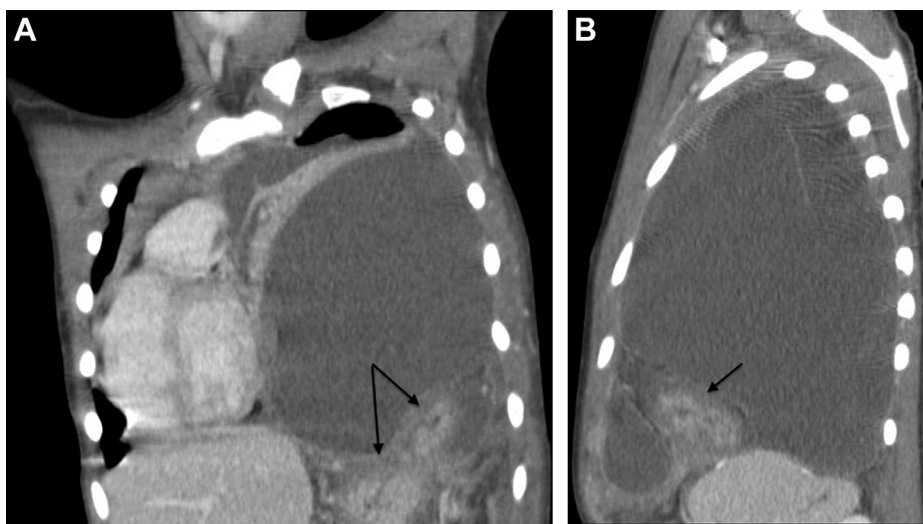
CT scan of the chest showing large simple left thoracic fluid collection with evidence of trans-diaphragmatic herniation of abdominal contents. A) Arrows demonstrate stomach traversing the diaphragm; B) arrow demonstrates intra-thoracic gastric fundus.
